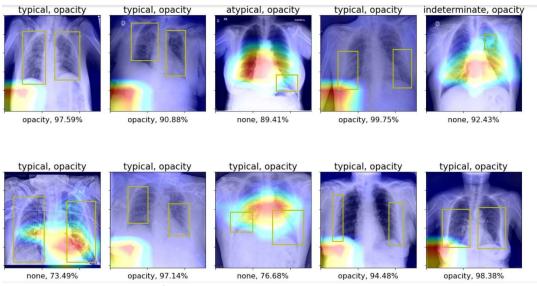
CHEST X-RAY NET RESULTS
